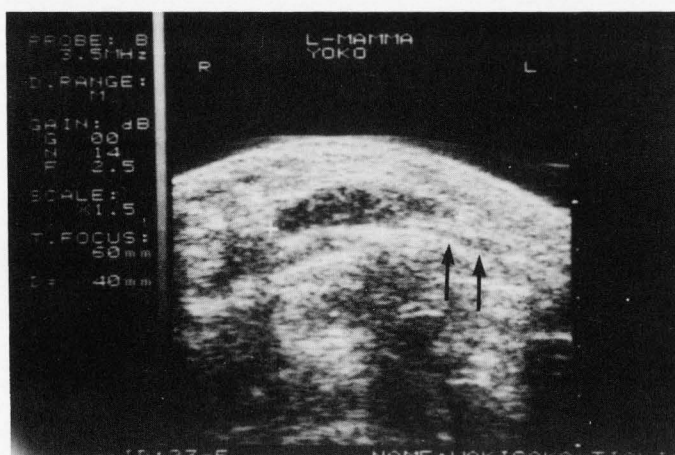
Ultrasonography of the left breast tumor.
